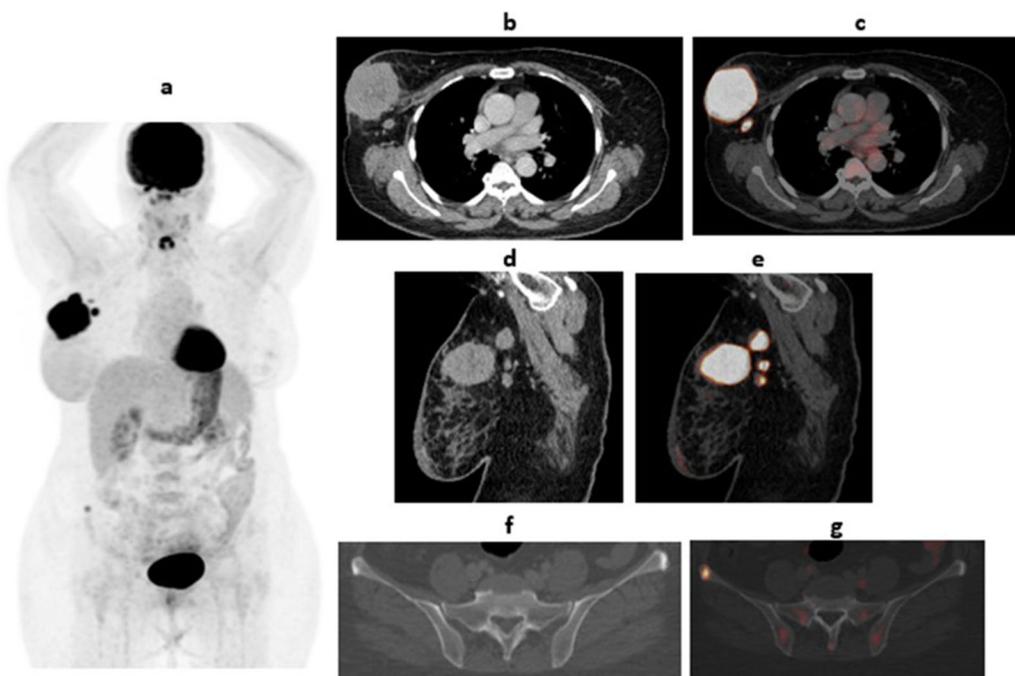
A 61-year-old female patient presented with recently diagnosed right breast cancer (invasive ductal carcinoma). a Whole-body PET MIP image revealed large active right breast mass with multiple active ipsilateral axillary LNs as well as other less active right pelvic bone focus. b, c, d, e axial and sagittal CECT and fused PET/CT images revealed large right breast heterogeneously enhancing hypermetabolic upper outer quadrant mass, measuring 77 × 56 × 66 mm and achieving 23 SUVmax as well as multiple enlarged hypermetabolic right axillary lymph nodes, the largest measures 23 × 24 × 26 mm and achieving 20.5 SUVmax. f, g axial pelvic CT and fused PET/CT images (bone window) revealed small metabolically active right iliac bone deposit in fused PET/CT image, achieving 6 SUVmax, not appreciated in CT image alone
